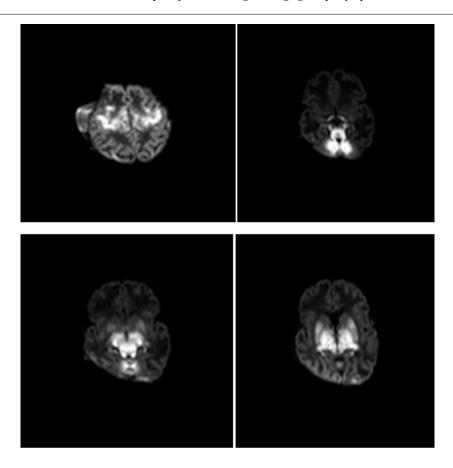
DWI images show areas of restriction diffusion in bilateral cerebral hemispheres, cerebellum white matter, brain stem, thalami and basal ganglia
